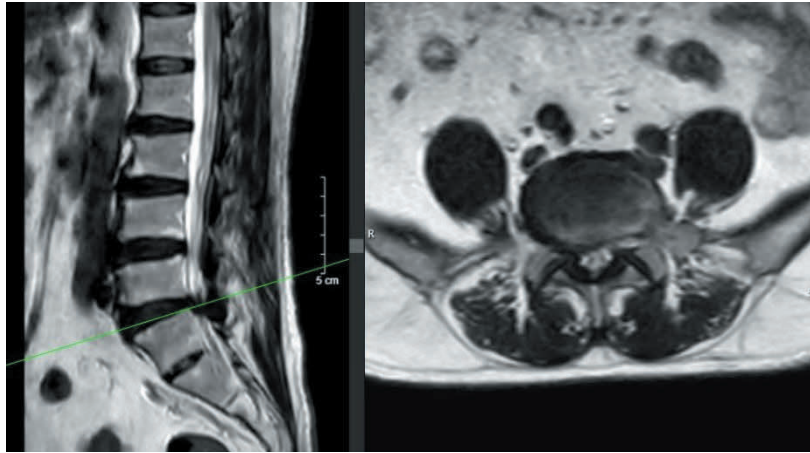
MRI image of Lumbar spine from August 8, 2024: disc protrusion at L4/5 with right paracentral convexity, causing moderate (2/4) spinal canal narrowing.
